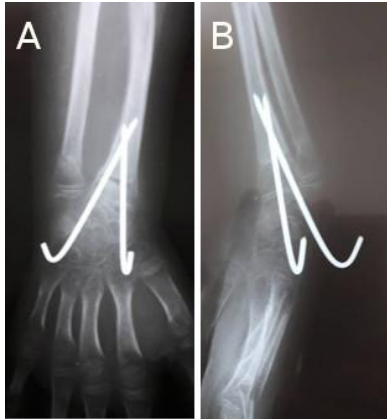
An X-ray of the anteroposterior (A) and lateral (B) presentation after the fixation with the Sommer - pins
